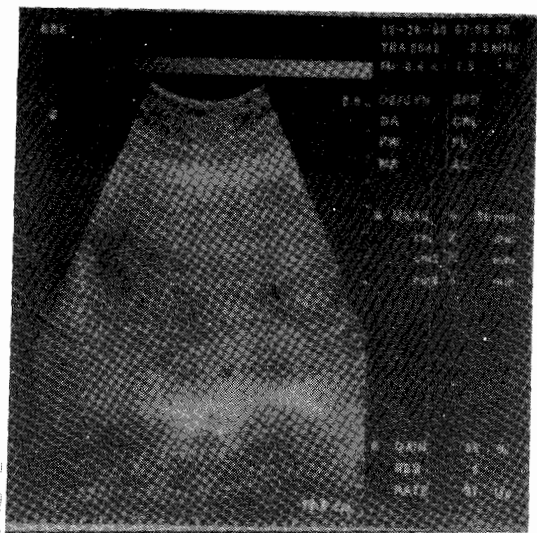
Abdominal ultrasound showing an empty uterus.
